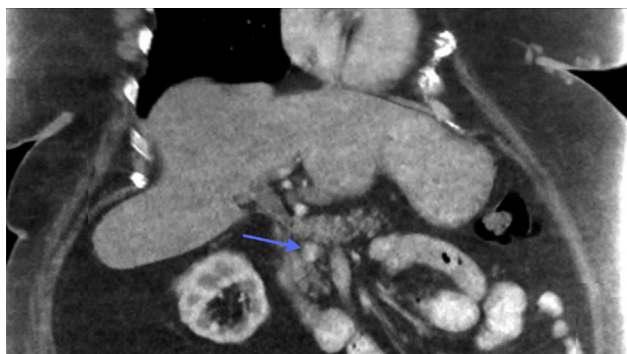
CT image of arterial enhancing lesion in the pancreatic head.
